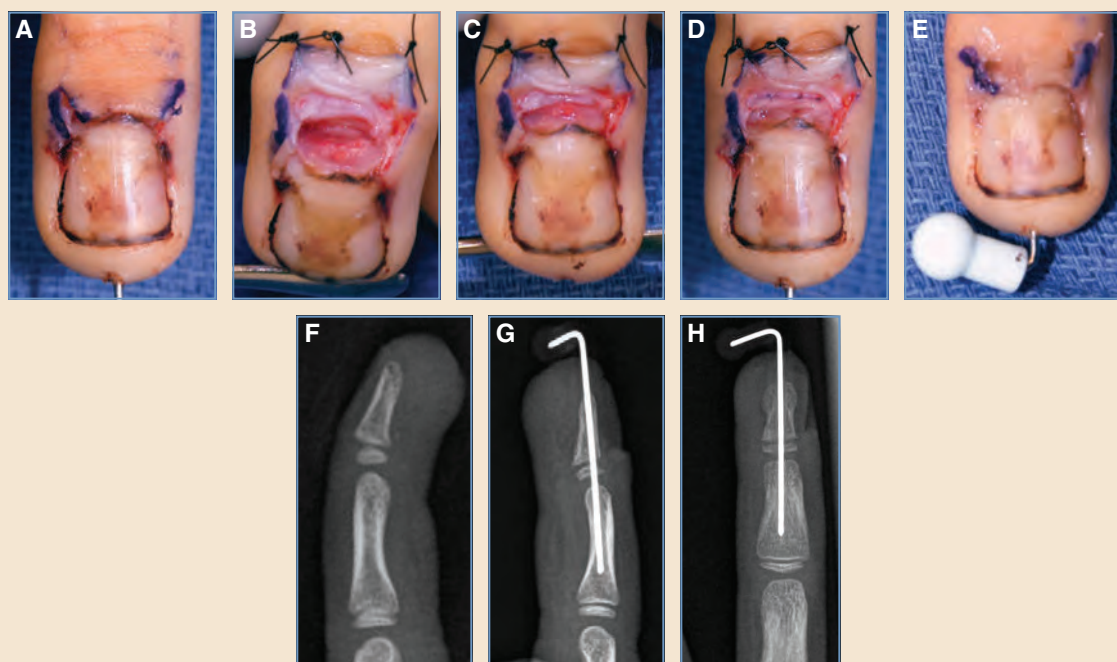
Correction of a Seymour fracture. A, Incisions to reflect back the eponychial fold. B, Germinal matrix caught inside the fracture. C, Germinal matrix delivered out of the fracture gap. D, Germinal matrix repaired to the terminal tendon. E, Eponychial fold incisions repaired with cyanoacrylate glue. F, A preoperative radiograph shows an apex dorsal angular deformity through the physis. G and H, Postoperative radiographs show the pins in place.
